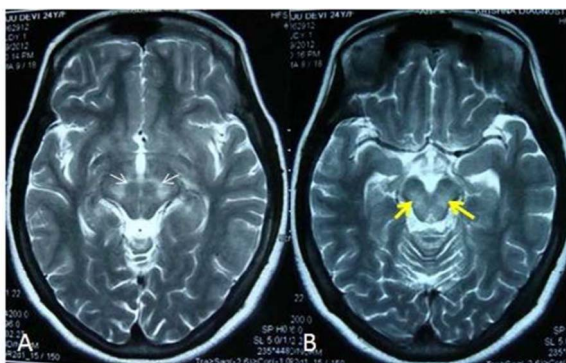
T2-weighted axial MRI brain shows (A) hyperintensity in bilateral cerebral peduncles and red nuclei, (B) hyperintensity in the midbrain involving substantia nigra (yellow arrows).
